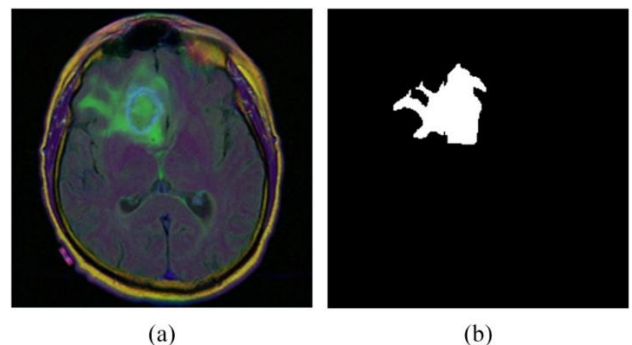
Original MRI image (a) and its corresponding mask (b) from the LGG segmentation dataset
